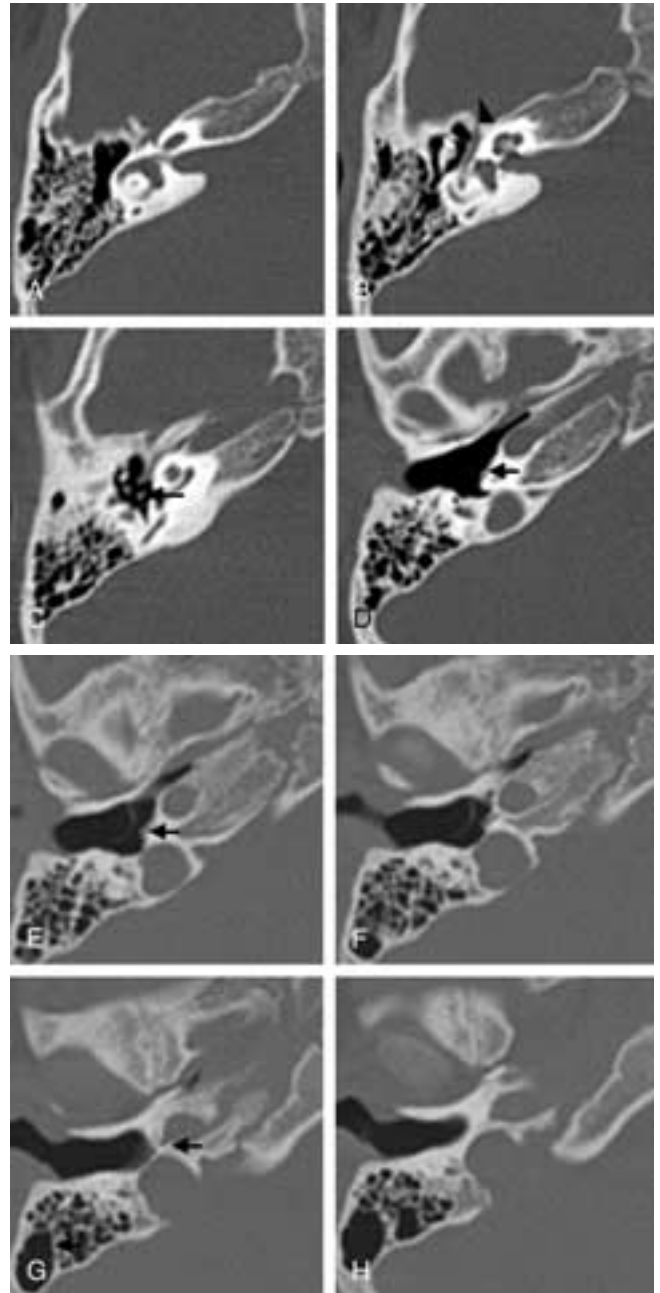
PSA. A to H, Axial CT images from superior to inferior. The small vascular channel can be seen leaving the vertical carotid at G (*arrow*) and can be followed along the lower medial wall of the middle ear (D to F) (*arrows*). Level C is at the plane of the stapedial crura. The vessel cannot be clearly separated from the anterior crus of the stapes. After following the facial nerve canal, the small vascular channel reaches the middle cranial fossa at level B (*arrowhead*). Level A represents the position of the geniculate ganglion turn of the facial nerve canal. (Modified from Thiers FA, Sakai O, Poe DS, Curtin HD. Persistent stapedial artery: CT findings. *AJNR* 21(8):1551–1554, 2000, Figure 2, p. 1553, © American Society of Neuroradiology [www.ajnr.org].)
